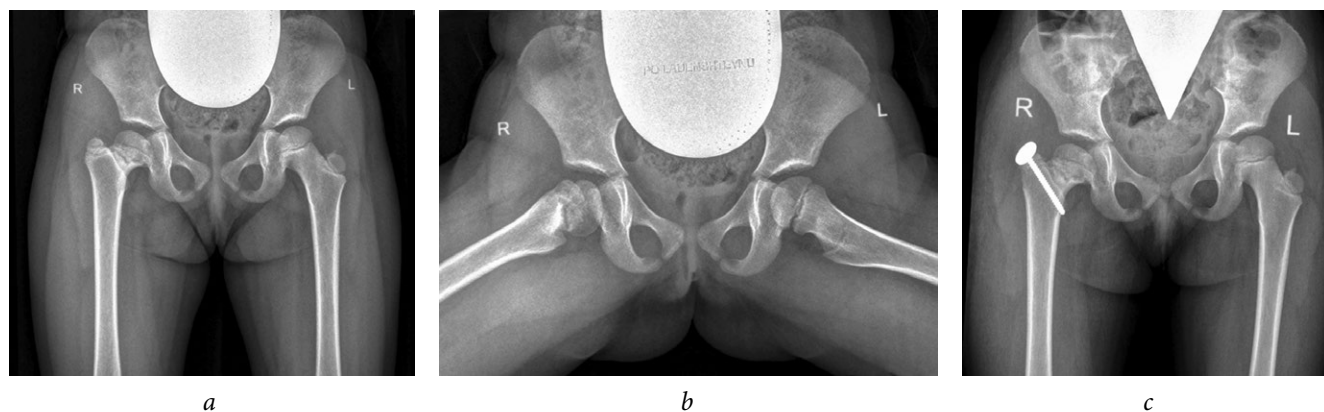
Radiographs of patient G (4 years old) diagnosed with complications of septic arthritis of the hip joint, emerging high position of the greater trochanter on the right, and multiplanar deformity of the femoral neck with eccentric growth of the epiphysis posteriorly: *a, b*, before surgery; *c*, immediately after trochanteric epiphysiodesis on the right
